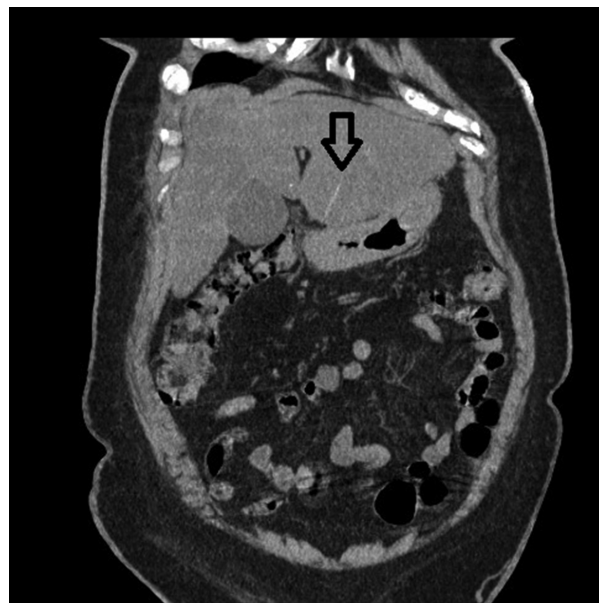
Abdominal CT scan showing toothpick in the liver (black arrow).
